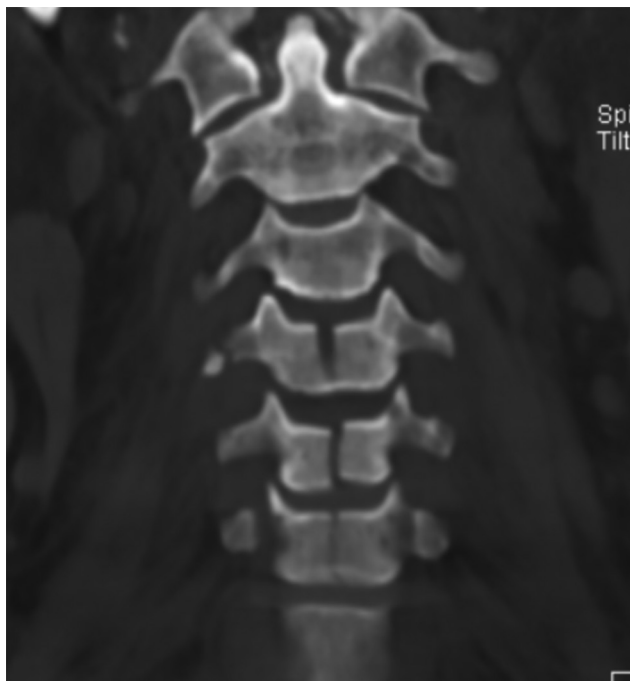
Noncontrast computed tomography (NCCT) cervical spine coronal section showing the sagittal split fracture of C4 to C6 cervical vertebral bodies.
